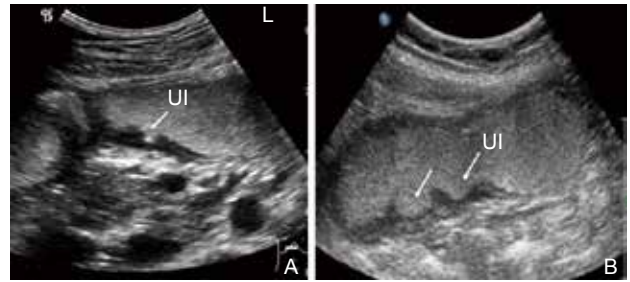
Gastric ulcer. (A) contrast ultrasound imaging shown superficial gastric ulcer (arrow); (B) Contrast ultrasound imaging identified deep gastric ulcers (arrows). Ul, ulcers.
